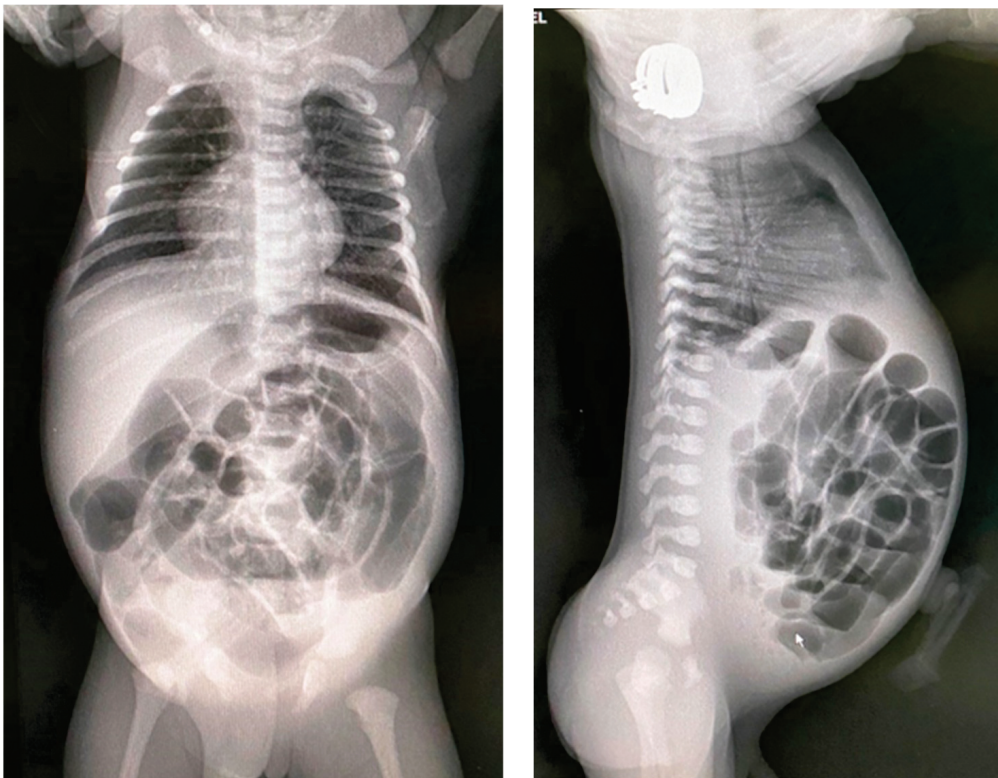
Abdominal X-ray showing dilated intestinal loops and a ground glass appearance; antero-posterior incidence and profile incidence.
